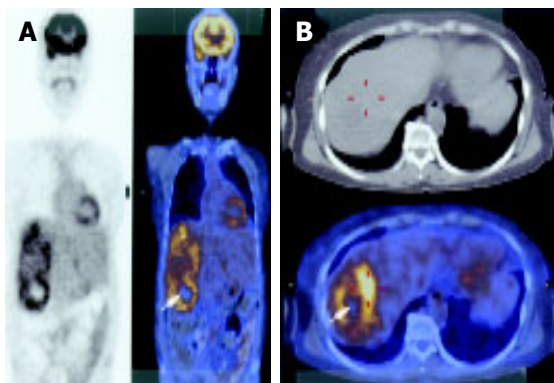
A: 18 F-FDG PET showed high uptake at the tumor without any distant lesions. The silent area in the center of the tumor suggests central necrosis (arrow); B: The highest uptake area measured 4.8 SUV (red line mark).
